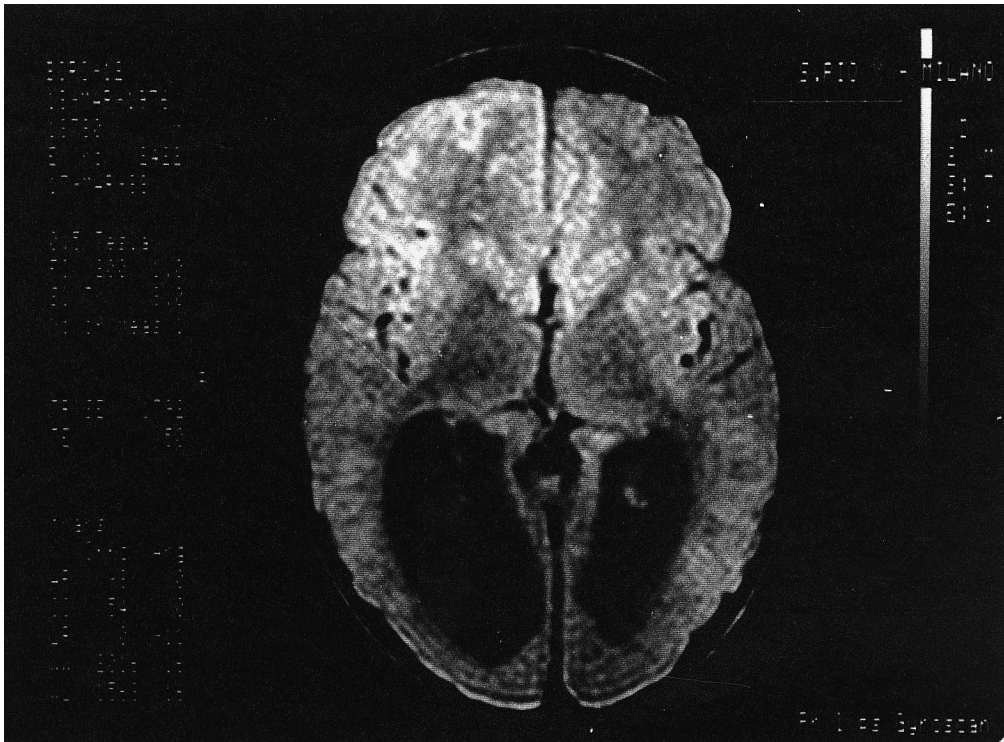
Magnetic resonance image of R.B.'s brain in horizontal plane.
